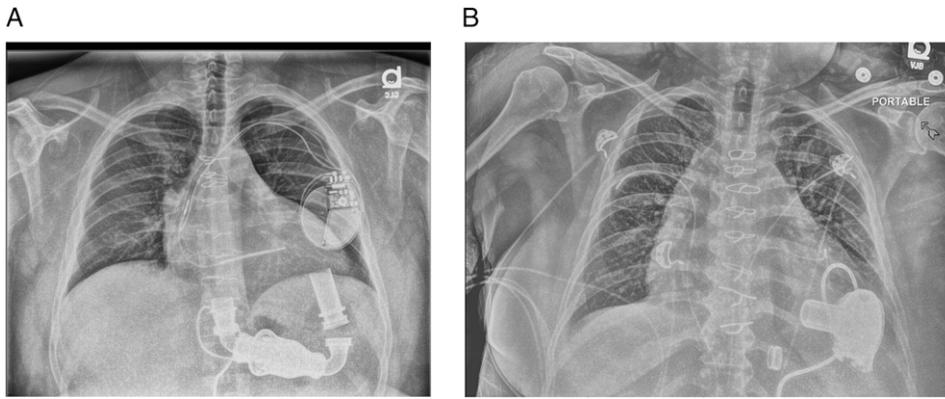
A, Chest radiograph of an axial-flow LVAD. B, Chest radiograph of a centrifugal-flow LVAD. See Figure 1 legend for expansion of abbreviation.
